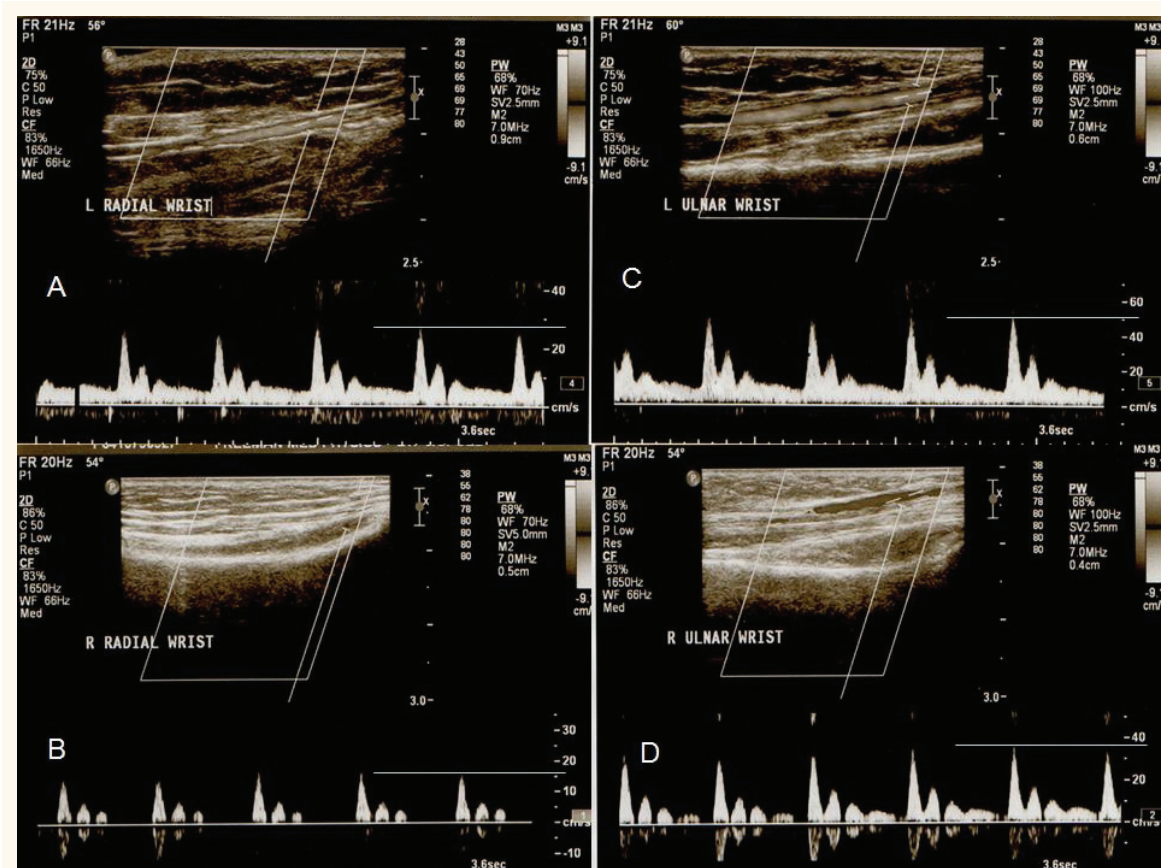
Pulse wave Doppler pictures of arterial blood flow at the wrist in an 11 year-old boy showing reduced Doppler flow velocity in the radial arteries compared to the ulnar arteries (Left radial artery [A] 28 cm/sec; Right radial artery [B] 15 cm/sec; Left ulnar artery [C] 50 cm/sec; Right ulnar artery [D] 38 cm/sec).
